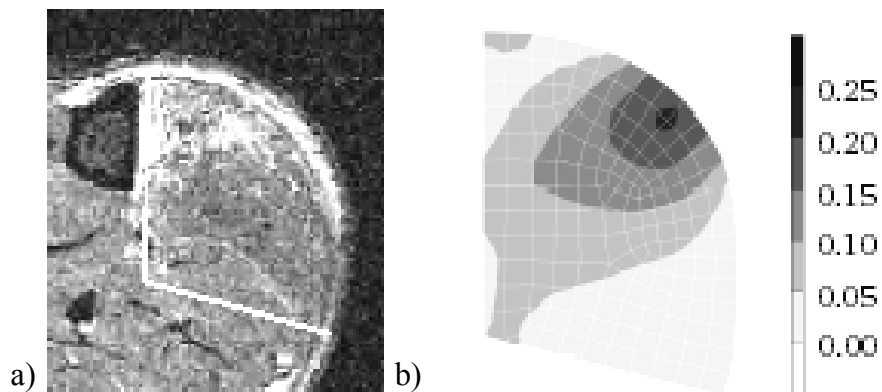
Comparison of the area of muscle damage in a) transverse MR image with b) maximum shear strain distribution for the reference model [28].
